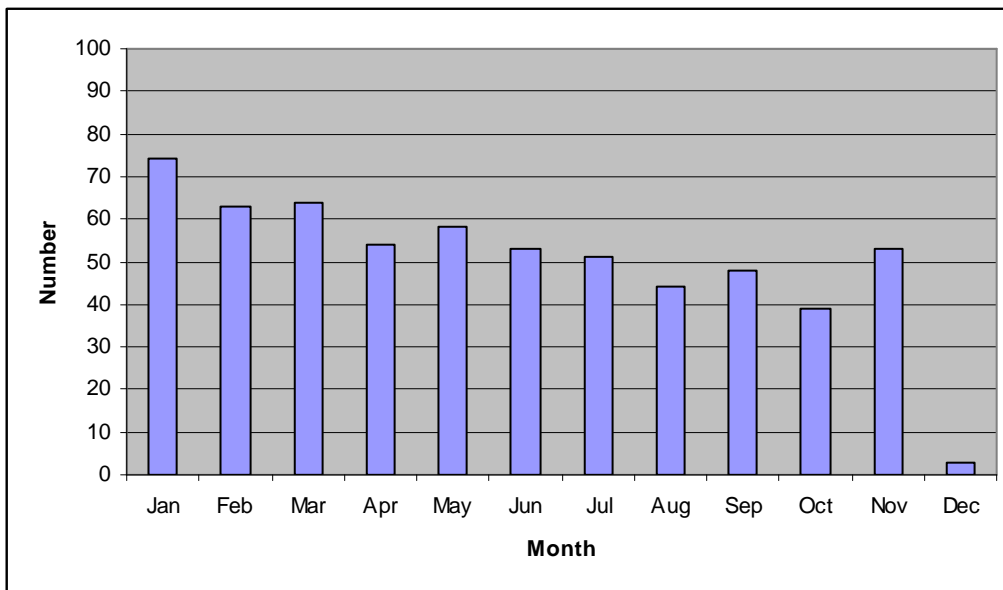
Ultrasound examination
